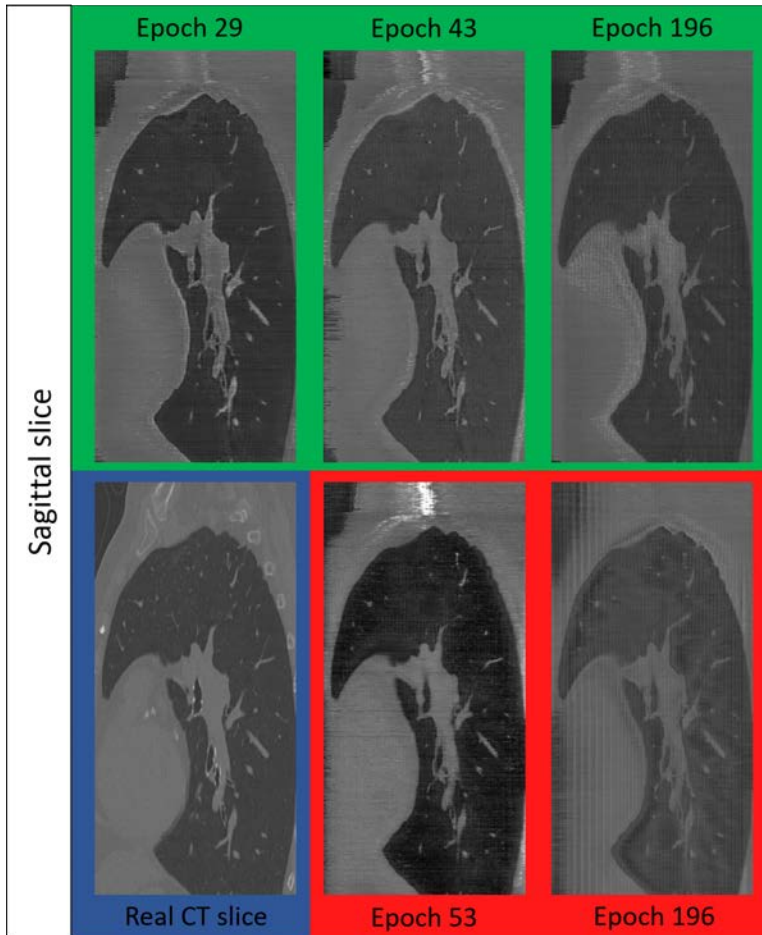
Augmented sagittal CT-scans slices for Pareto and non-Pareto epochs.
